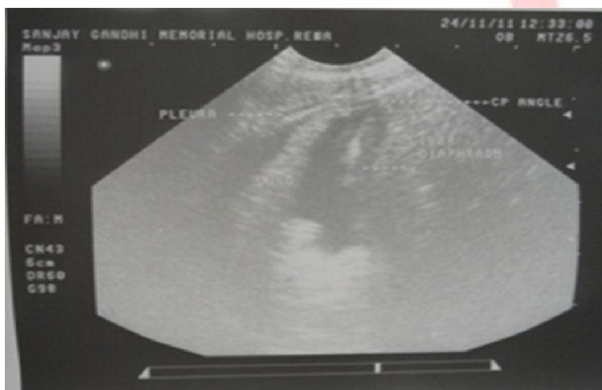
Ultrasound showing Lung, Pleura and Diaphragm
